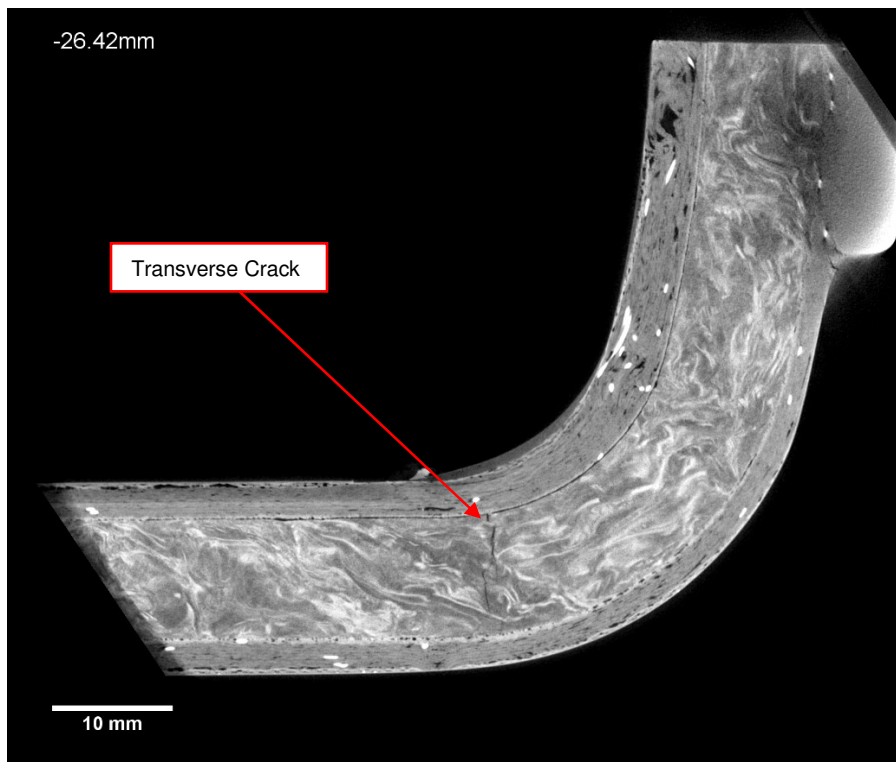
Section through Blue blade root filler using X-ray tomography, showing transverse crack
